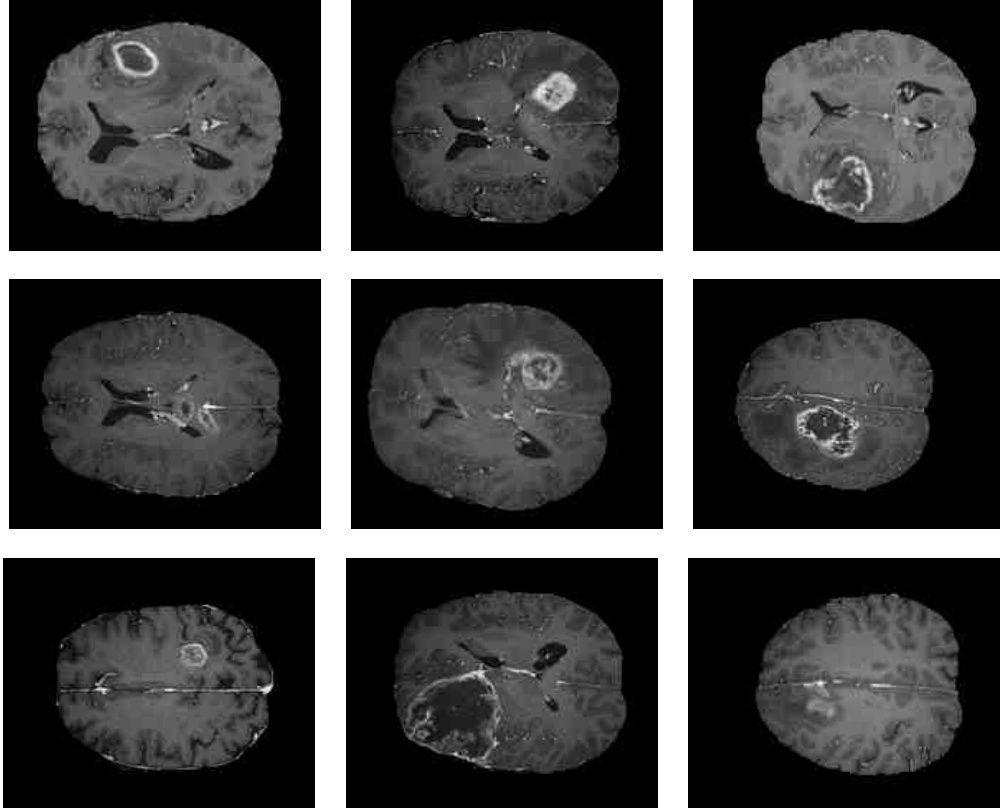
Examples of real T1c-weighted MR images
